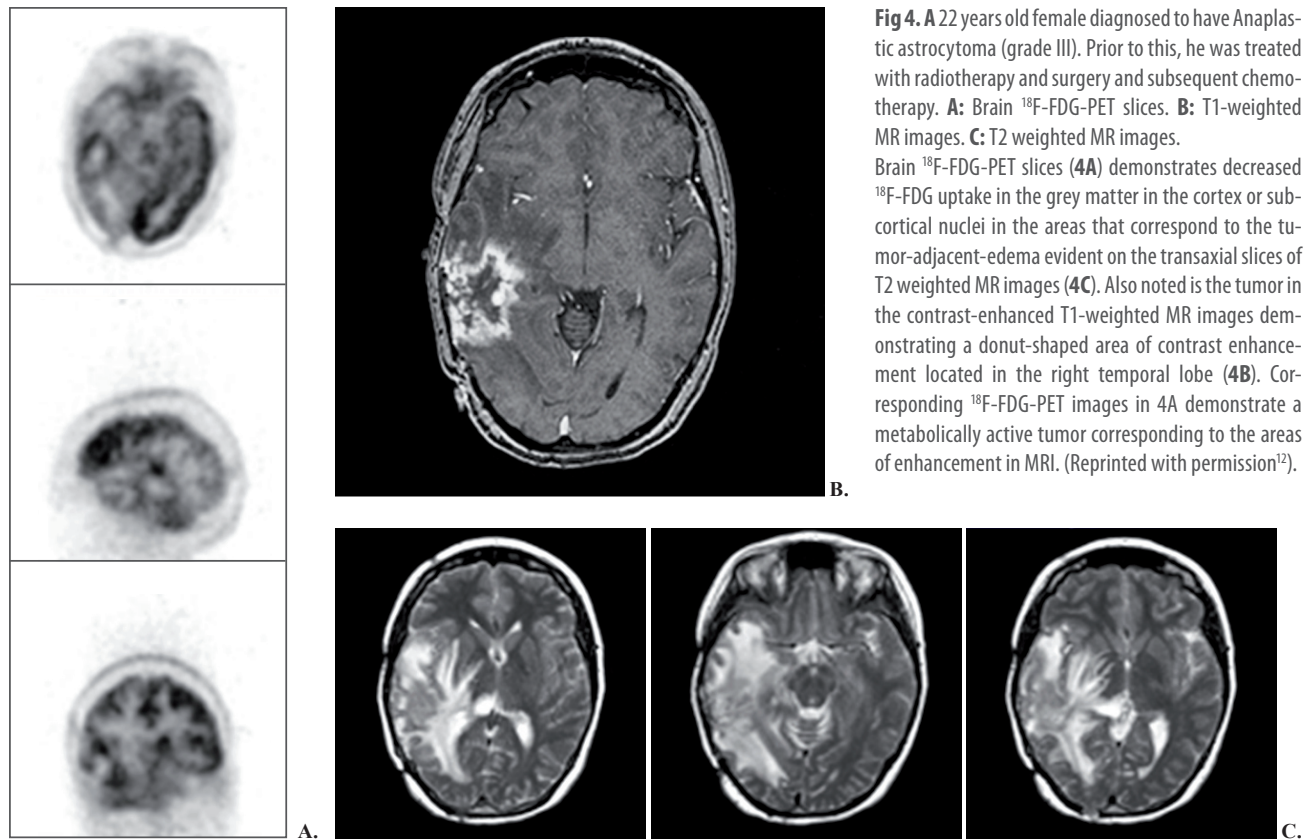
A 22 years old female diagnosed to have Anaplastic astrocytoma (grade III). Prior to this, he was treated with radiotherapy and surgery and subsequent chemotherapy. A: Brain ^{18}F -FDG-PET slices. B: T1-weighted MR images. C: T2 weighted MR images.
